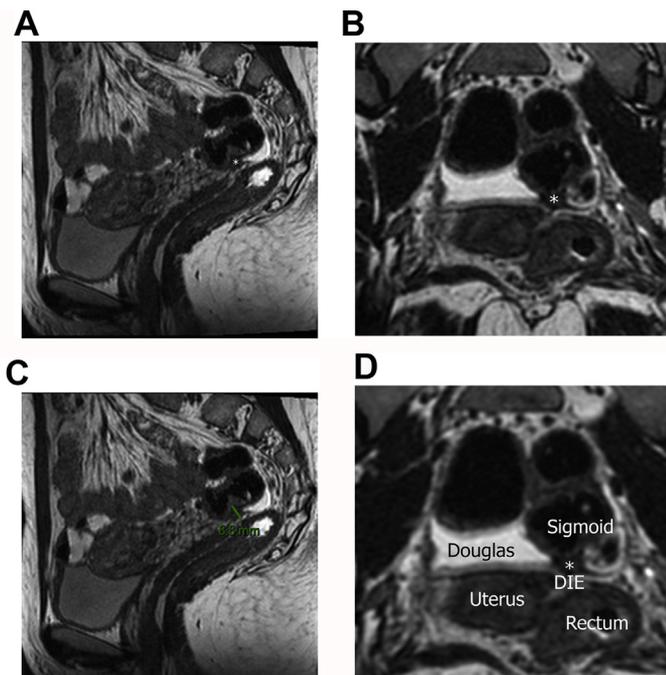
A 36-year-old patient with chronic pelvic pain, dysmenorrhea, painful defecation during menstruation, constipation, and diarrhea. Sagittal and coronal pelvis MRI 3D-T2W images show a discrete thickening of the torus uterinum and USL in low signal intensity on T2 intensity with a left-sided spiculated nodule (*) tethering the adjacent sigmoid. At surgery, resection of torus uterinum and USL with adhesiolysis with minimal shaving of the sigmoid serosal.
